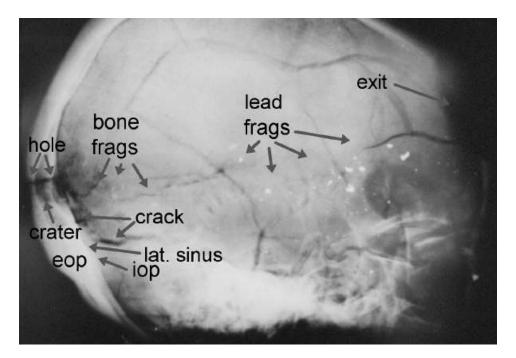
This test skull was shot with a Mannlicher-Carcano (full metal-jacketed bullet) by the Biophysics Division at Edgewood Arsenal. The bullet enters at the rear, where the "hole" is identified. Notice especially that *almost all of the fragments lie far from the entry site*. This is exactly the opposite of the JFK lateral X-ray, in which most of the metallic debris lies in the first half of the debris trail (assuming a frontal entry). Also note that the largest fragments lie farthest from the entry site.
